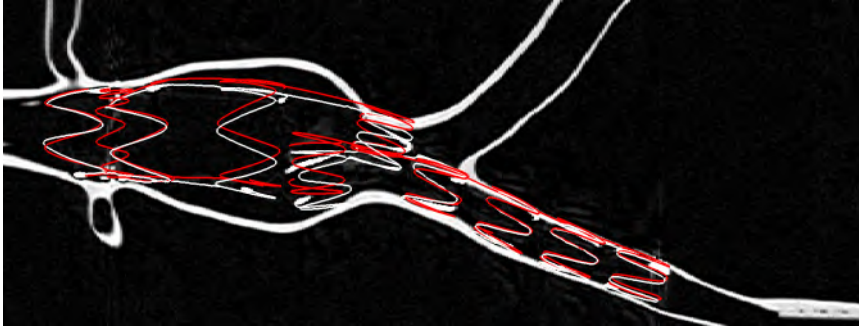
Qualitative visual comparison between 3D models of the experimental deployment (white) and the virtually deployed stent graft (red), with a coronal CT-slice background as a plane in space, obscuring the lower half of the stents.
